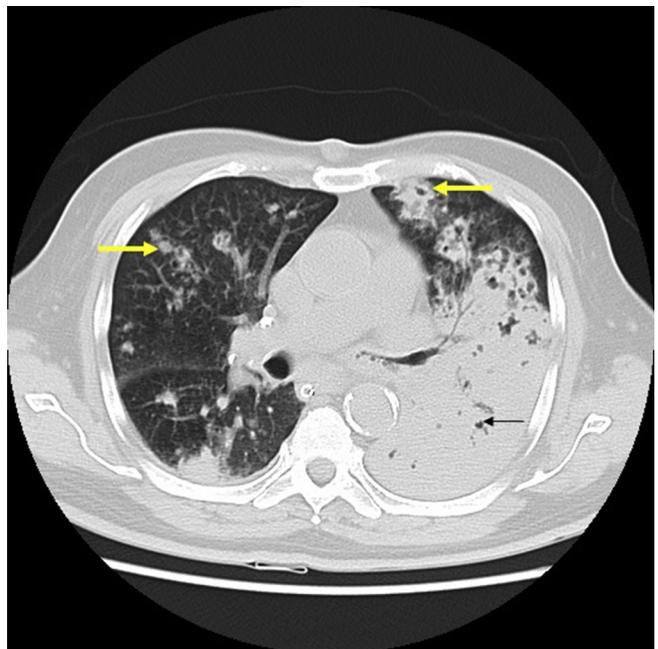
CT transverse section (lung window) shows bilateral nodular lesions (yellow arrows) and subtle air bronchogram in large area of consolidation (thin arrow) on left.
